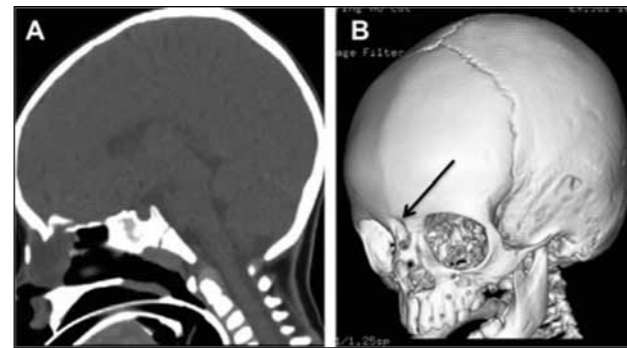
A) Sagittal CT and B) 3D reconstruction showing a left anterior nasal glioma (nasal glial heterotopia) in a 10 month old child, with extension through the nasal bones (black arrow). This was resected via an entirely endoscopic transnasal approach.
